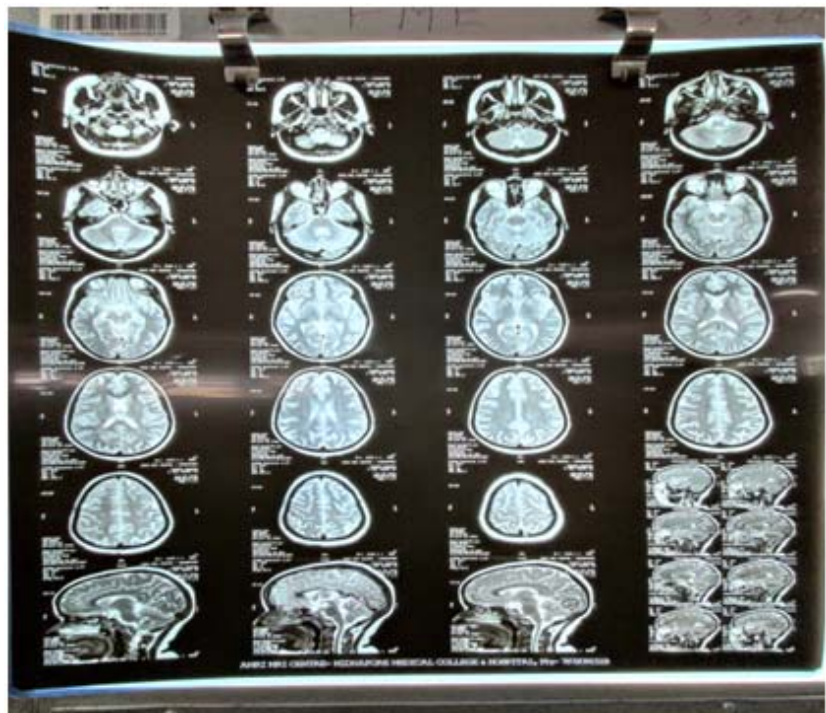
MRI of brain showing normal sized ventricles
